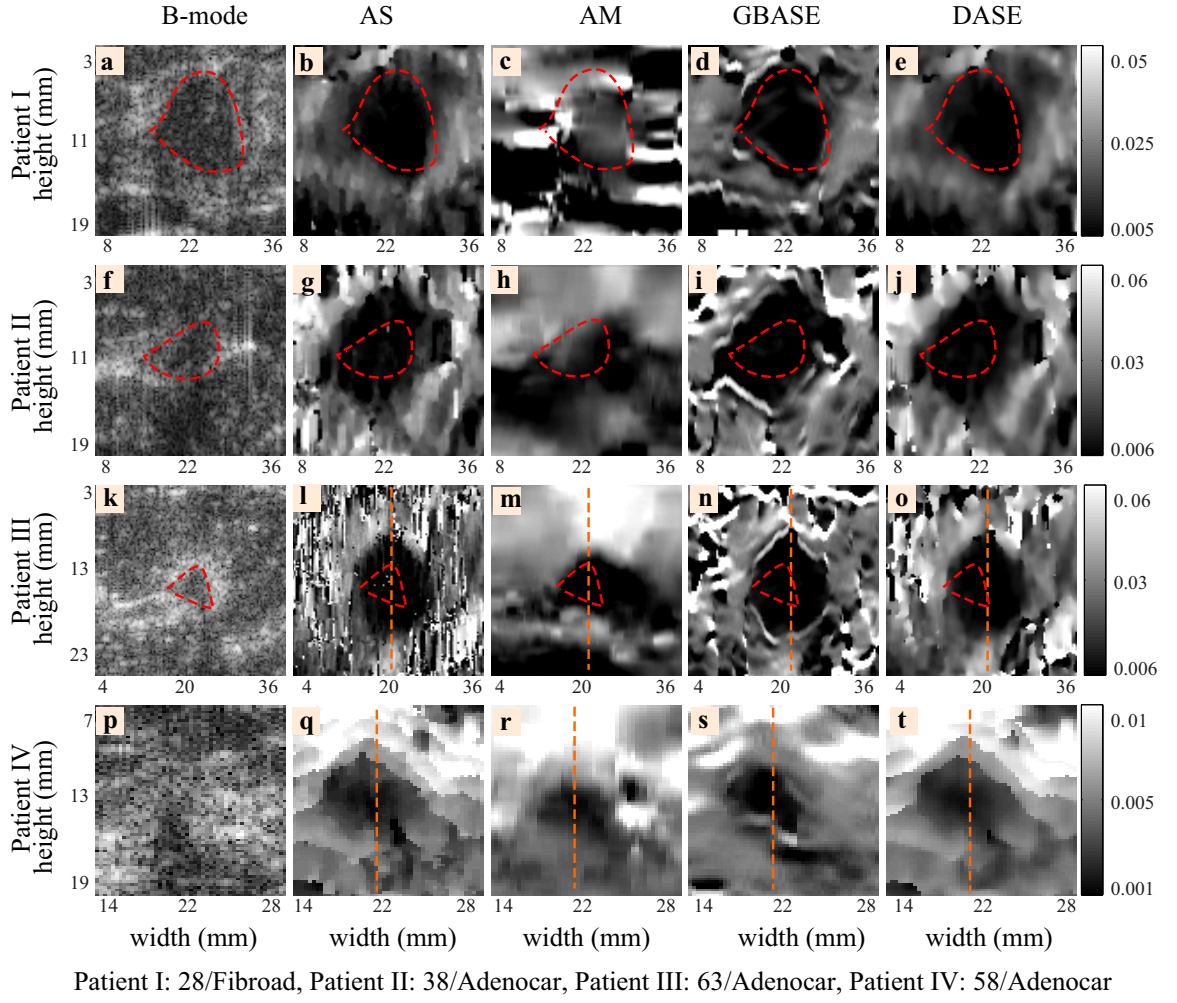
Strain images generated by different methods using *in vivo* breast ultrasound data. (a), (f), (k), (p) represent B-mode images of four patients. Results (b), (g), (l), (q) are produced by the AS method; (c), (h), (m), (r) are produced by the AM method; (d), (i), (n), (s) are produced by the proposed GBASE ( $L_l=3$ ,  $\chi_l=0.25$ ,  $\nu=0.5$ ) and (e), (j), (o), (t) are produced by the proposed DASE ( $L_a=3$ ,  $L_l=3$ ,  $\chi_a=\chi_l=0.25$ ,  $\nu=0.5$ ). The red dashed contours are drawn to compare the lesion sizes exposed in strain images with that of their corresponding B-mode images. For patient IV the shape of the lesion is not understood. The size of the malignant objects in the strain images are larger than that in the corresponding B-mode images.
